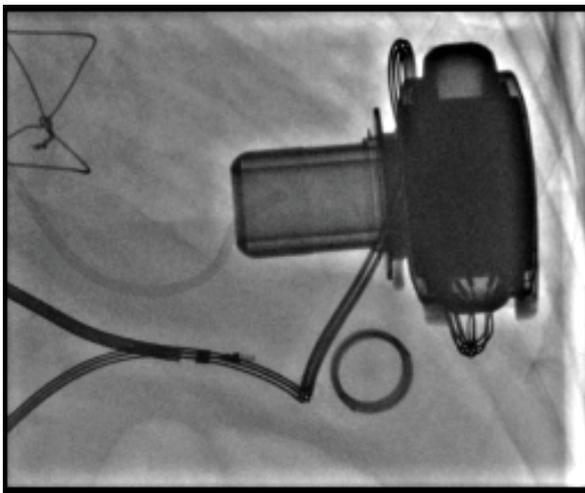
Intraventricular infusion of thrombolytic therapy: x-ray guided intra-ventricular thrombolysis with Alteplase. The injections were made directly into the device's inflow cannula through a 6Fr AL 2 catheter inserted through the radial artery.
